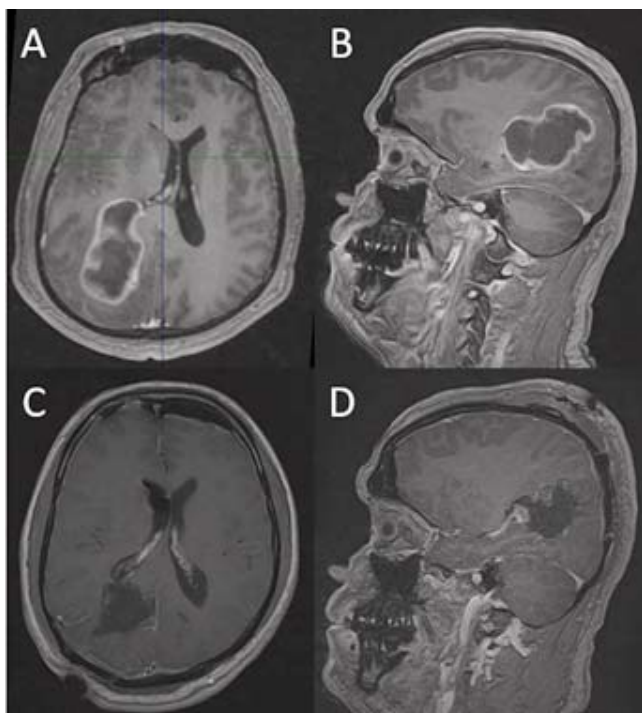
Preoperative axial and sagittal post-contrast T1-weighted MRI demonstrating a heterogeneously enhancing right posterior parietal glioblastoma (A & B). Postoperative axial and sagittal post-contrast T1-weighted MRI demonstrating gross total resection of the enhancing lesion (C & D).
